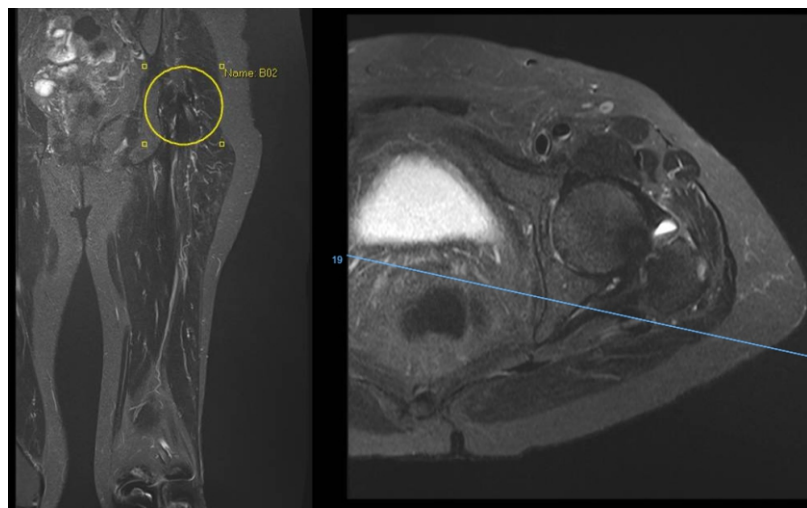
Magnetic resonance imaging of left thigh turbo inversion recovery magnitude sequence coronal and transverse views.
